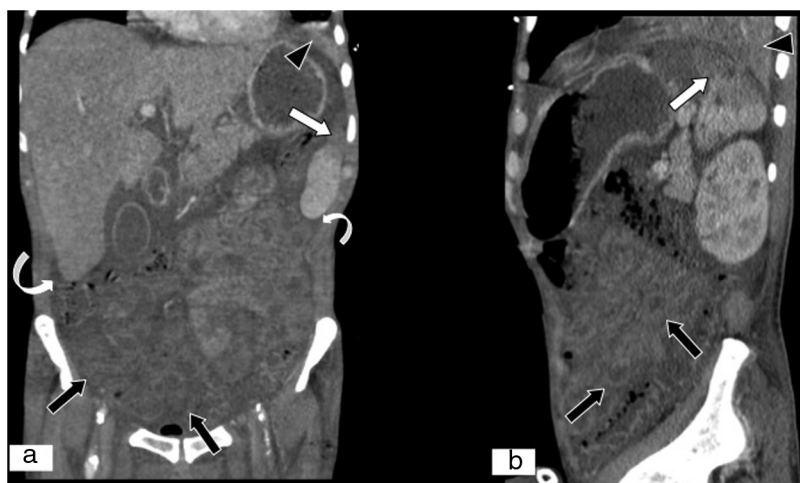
Non-occlusive mesenteric ischaemia in a patient with septic shock. (A) MPR on a coronal plane. (B) MPR on a sagittal plane in an abdominal and pelvic CT scan. Decreased attenuation at the superior-lateral end of the spleen due to infarction in a context of septic shock (white arrows). Decreased parietal uptake by loops of small intestine and colon due to hypoperfusion secondary to low output due to septic shock (black arrows). Presence of free fluid (curved white arrows). Alveolar condensation in left lower lobe (black arrow tips).
